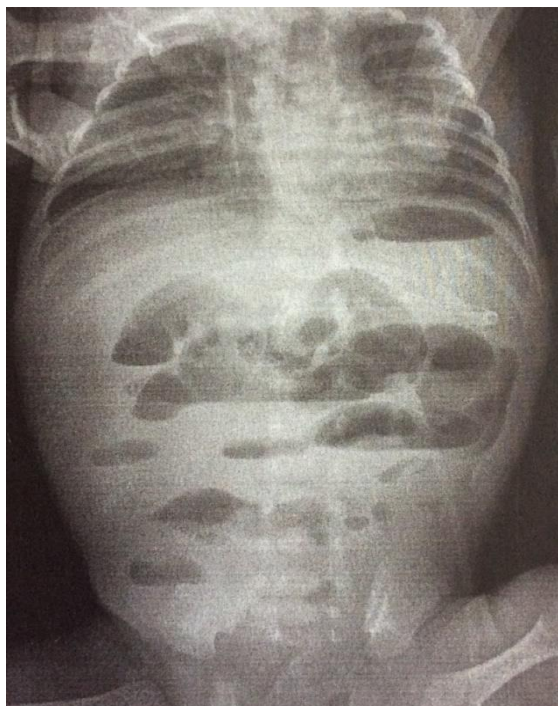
Plain Abdominal Radiography showing multiple hydroaeric levels due to small-bowel occlusion.
